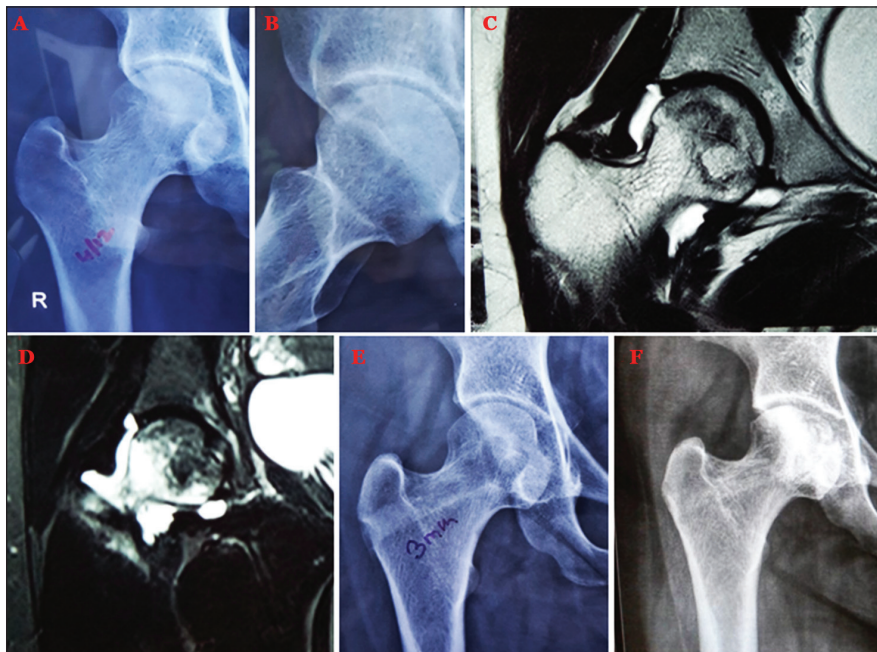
Patient F2. Preoperative anteroposterior radiographs of the right hip showing more than 90% involvement of the medial, central, and lateral regions. There is no crescent (A, B). Preoperative magnetic resonance images (C, D). Anteroposterior radiograph at 3 months after treatment (E). Anteroposterior radiograph at 6 years after treatment (F).
